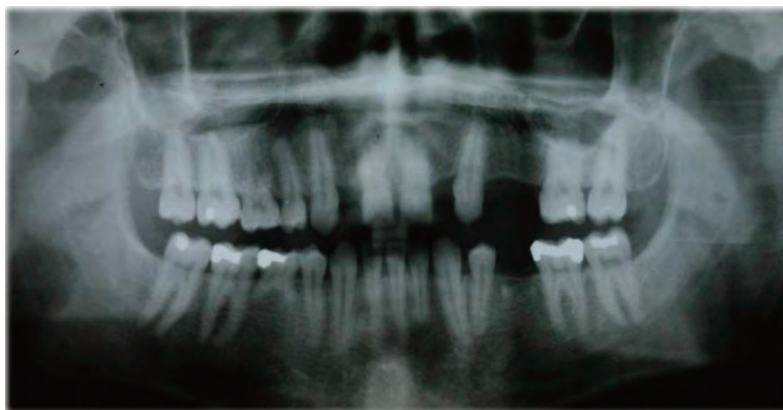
Preoperative panoramic radiograph showing the congenitally missing teeth
